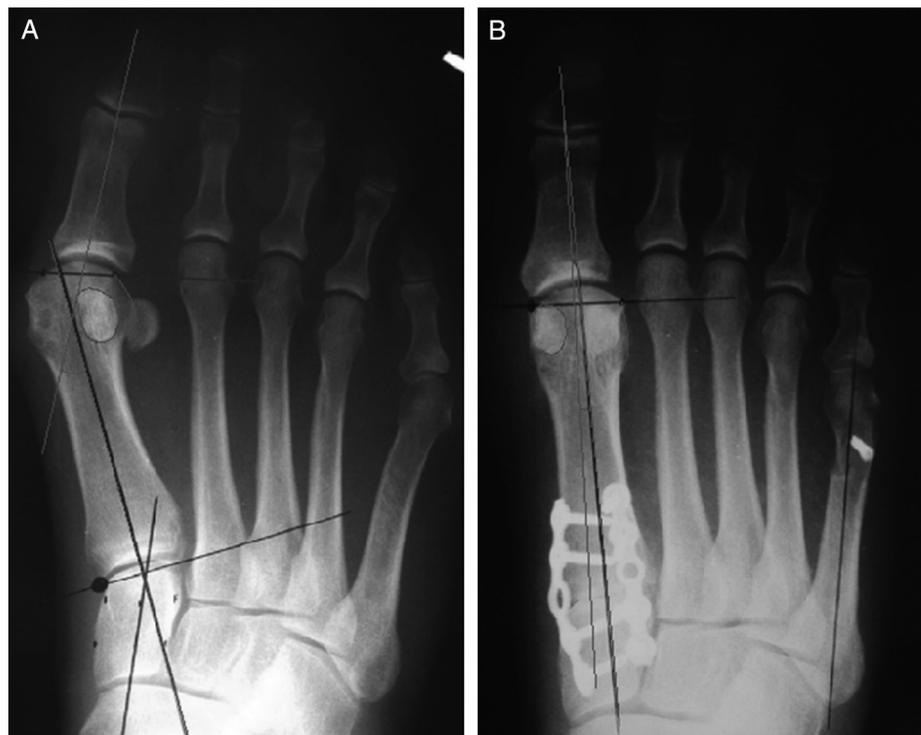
(A) A preoperative anteroposterior weightbearing radiograph. Note the hallux abductus angle, sesamoid position, prominence of the medial eminence, and observable roundness of the lateral metatarsal head. (B) A modified Lapidus procedure with transverse plane correction and rotational correction performed at the center of rotational angulation. No deformity was identified within the metatarsal. Observe the change in joint alignment, sesamoid position, prominence of the medial eminence, and shape of the lateral metatarsal head. Capsular balancing was not performed to produce this result.
